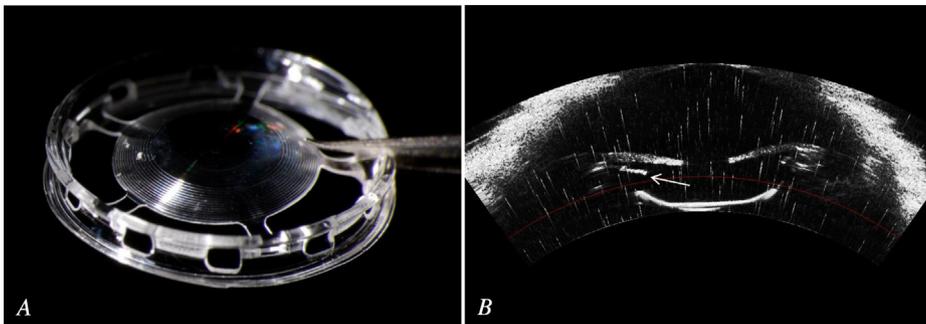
The Zephyr IOL. A: Anterior view of the modified Zephyr IOL. B: Ultrasound examination of an enucleated rabbit eye. The anterior capsule (arrow) is maintained at a distance from the anterior optic surface. Reprinted with permission of the *Journal of Cataract & Refractive Surgery*.⁴⁸
